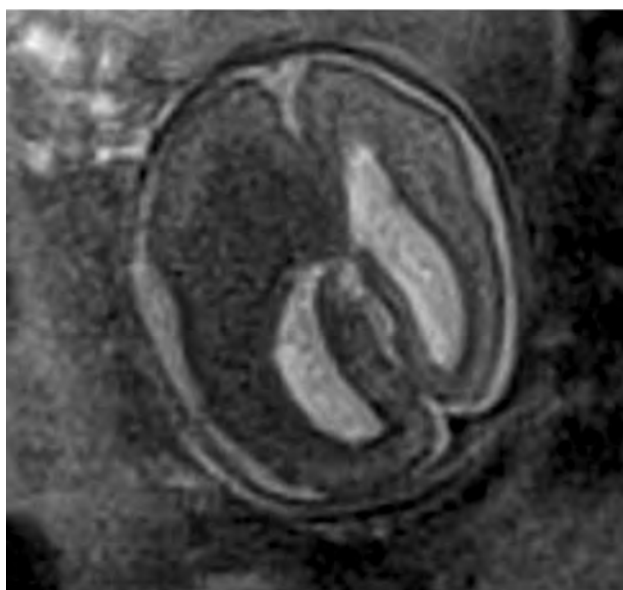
Twenty-two weeks' gestation. A 1.5T single-shot T2-weighted EPI demonstrates hemimegalencephaly and a dominant ipsilateral mass representing a possible coexistent subependymal giant cell astrocytoma. This was initially interpreted on screening US as a parenchymal hemorrhage. After the iuMR, dedicated fetal echocardiography the following day identified a single small rhabdomyoma.
